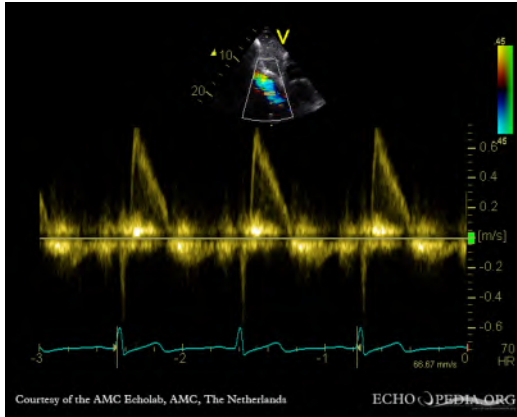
Pulsed-wave Doppler of the abdominal aorta flow with reversal flow during diastole. Adapted from [https://commons.wikimedia.org/wiki/File:Endocarditis_of_aortic_valve_E00258_\(CardioNetworks_ECHOpedia\).jpg](https://commons.wikimedia.org/wiki/File:Endocarditis_of_aortic_valve_E00258_(CardioNetworks_ECHOpedia).jpg). By CardioNetworks: Secretariat [CC BY-SA 3.0 (<https://creativecommons.org/licenses/by-sa/3.0>)].
